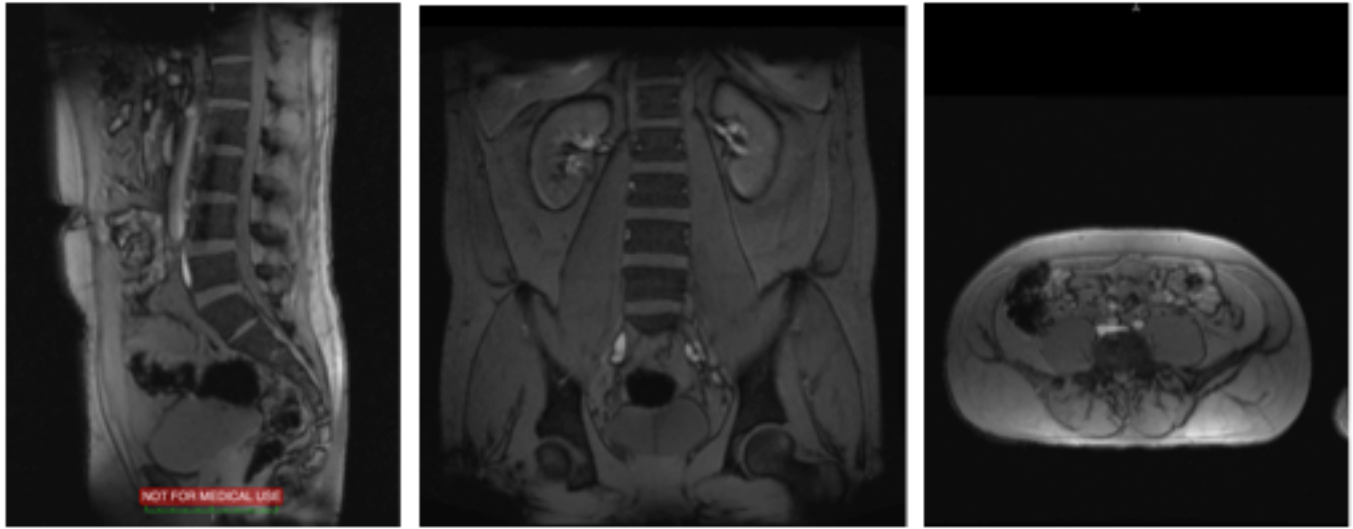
Localizer MRI Scan
